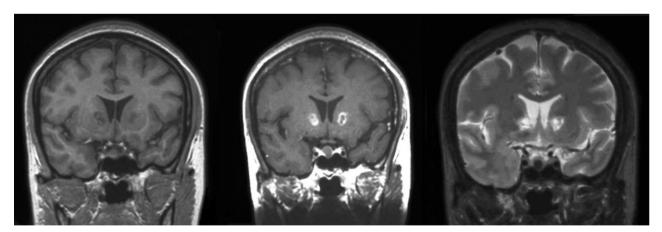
(Left panel) T1-weighted magnetic resonance imaging scan (coronal projections) taken 8 months postsurgery showing double shot bilaterally in the ventral portion of the internal capsule. (Middle panel) T1-weighted postgadolinium magnetic resonance imaging scan showing ring enhancement around the lesion. (Right panel) T2-weighted magnetic resonance imaging scan at same time point showing interstitial edema surrounding the lesion.
